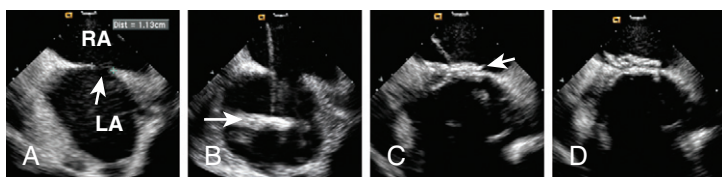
Intracardiac echocardiography in patient with atrial septal defect (ASD). A, Septal view, demonstrating the ASD (arrow), the right and left atria, and the superior and inferior rims. B, The left atrial disc (arrow) deployed in the left atrium. C, The right atrial disc (arrow) deployed in the right atrium. D, The device released, demonstrating good position.
